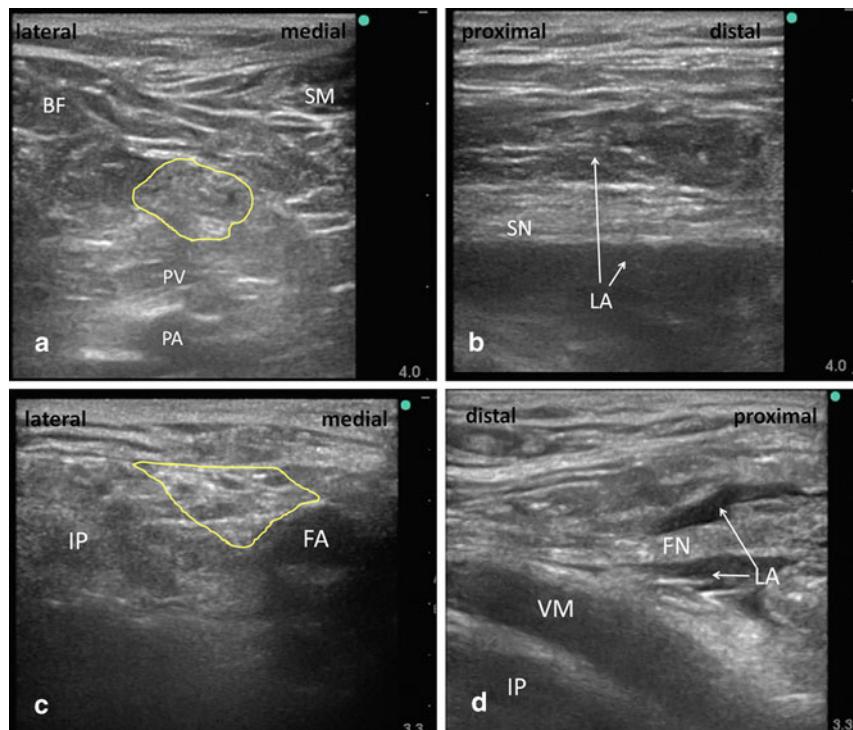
a Ultrasound view before the popliteal block (area surrounding sciatic nerve). b Ultrasound view after the popliteal block which was performed with 20 ml 1.5% lidocaine and 20 ml 0.5% ropivacaine in the prone position. Spread of local anesthetic above and below the femoral nerve was shown by placing the ultrasound probe parallel to the nerve (arrows). c Ultrasound view before the femoral nerve block (area surrounding femoral nerve). d Ultrasound view after the femoral nerve block which was performed with 10 ml 1%
